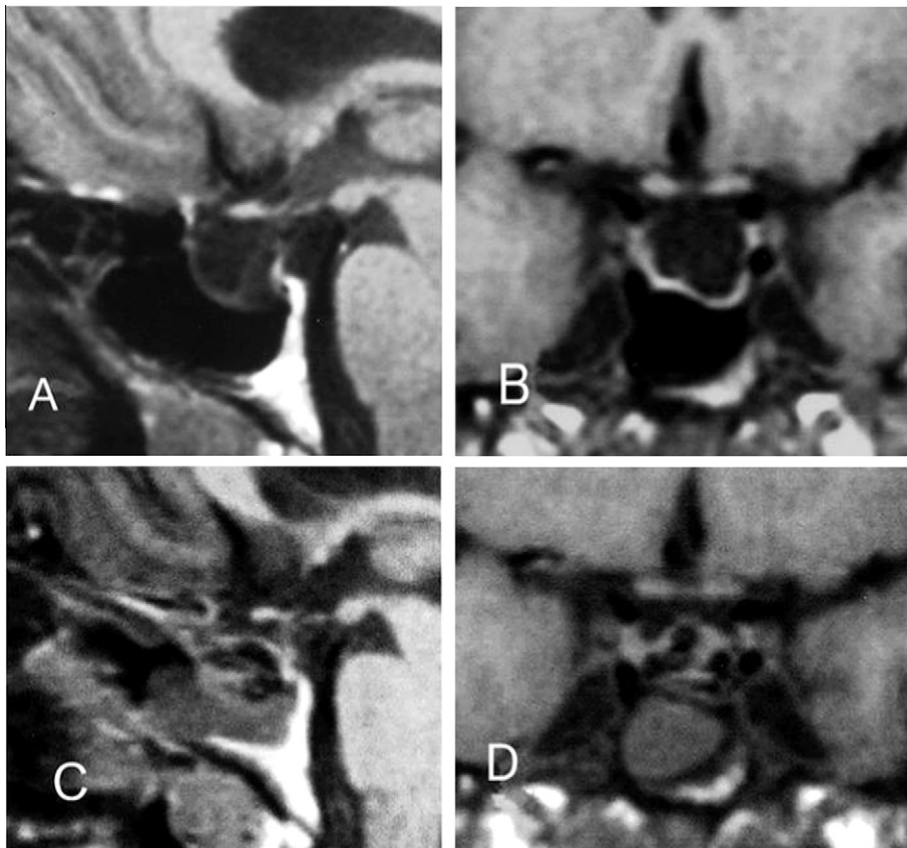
A & B: Preoperative sagittal and coronal T1-weighted MRI in patient with primary ESS showing downward traction of chiasm and the pituitary gland is flattened against the sellar floor, and the stretched pituitary stalk. C & D: Postoperative sagittal and coronal MRI of the same patient 6 months after extradural transsphenoidal packing of the sella with muscle & fat showing that the chiasm and pituitary stalk are in normal position.
